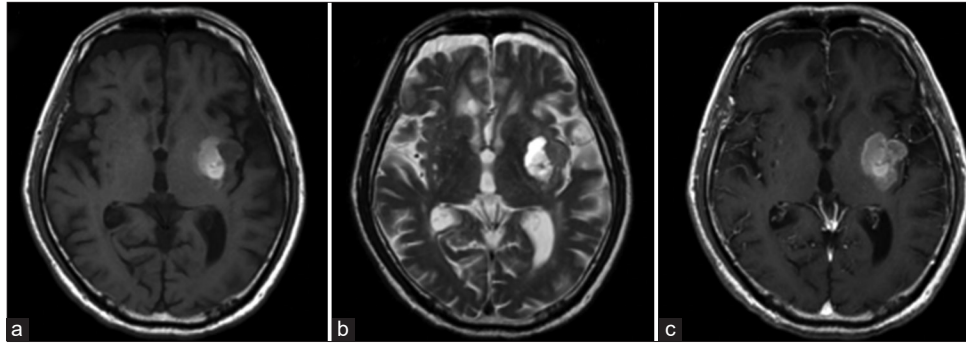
Postoperative T1-weighted images (a), T2-weighted images (b), and contrast-enhanced T1-weighted images (c) show that the mass is partially excised.
